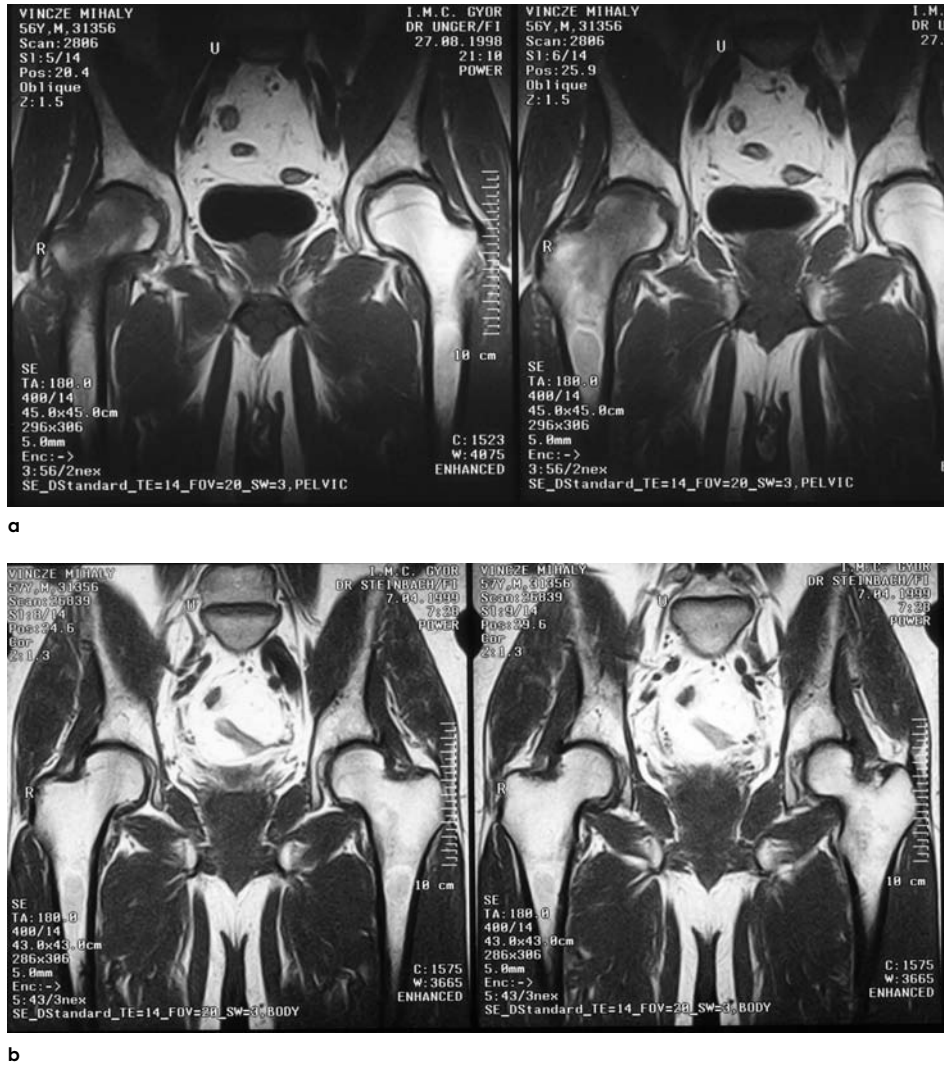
Transient ischemia of the hip as seen in MRI.
